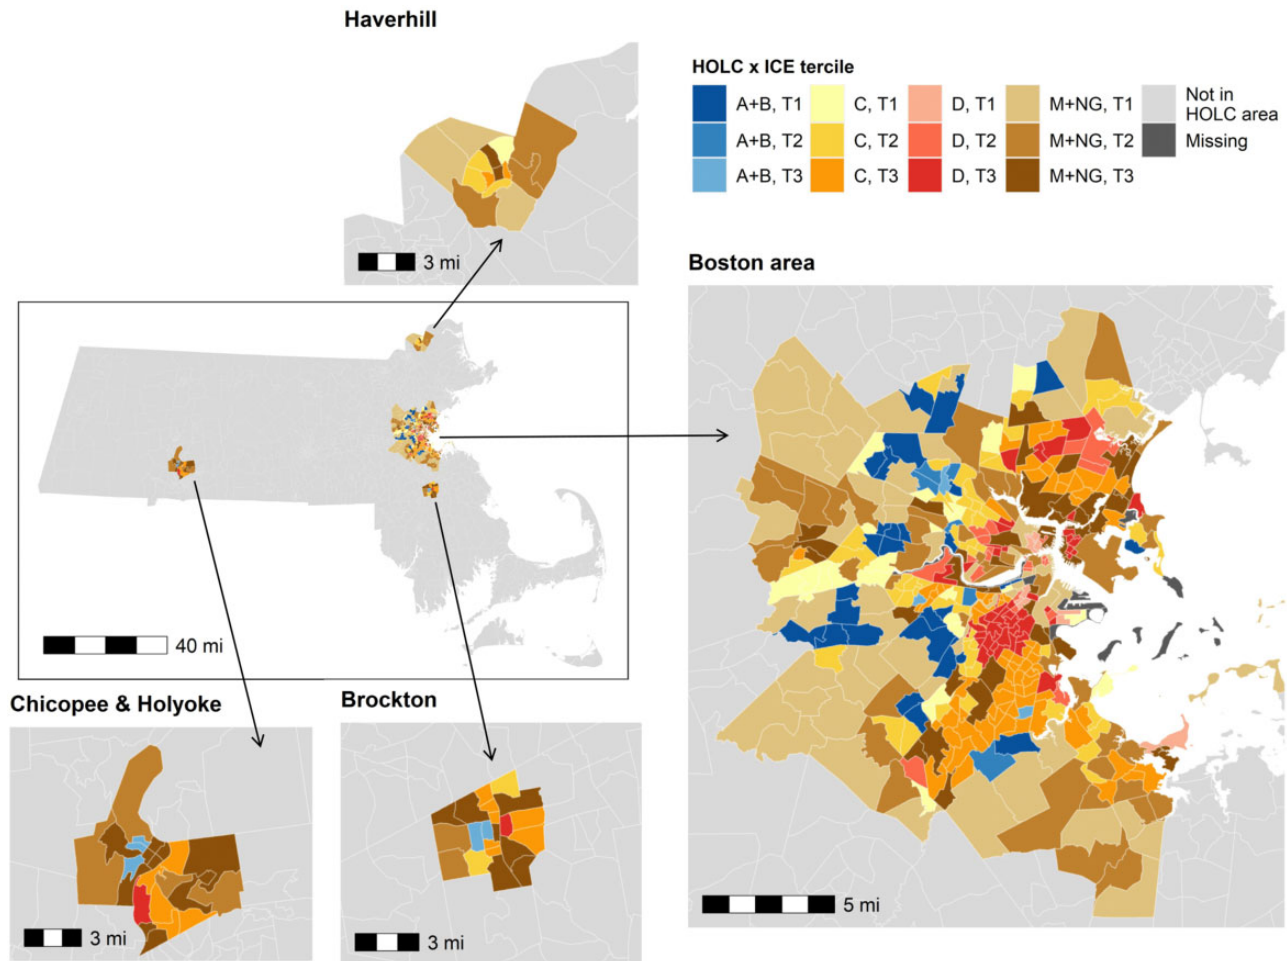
HOLC grade (1937-1938) by ICE for racialized economic segregation tertile (2005-2015) trajectories for Massachusetts CTs ($n = 474$), 2010 boundaries, in municipalities ($n = 28$) with 1930s HOLC maps. HOLC grade operational definition: A/Green = CTs whose land area is [(100% A) OR ($\geq 50\%$ A and $< 100\%$ A)]; B/Blue = CTs whose land area is [(100% B) OR ($\geq 50\%$ B and $< 100\%$ B)]; C/Yellow = CTs whose land area is [(100% C) OR ($\geq 50\%$ C and $< 100\%$ C)]; D/Red = CTs whose land area is [(100% D) OR ($\geq 50\%$ D and $< 100\%$ D)]; Mixed = no category with $\geq 50\%$; No grade assigned = $\geq 50\%$ of land area is unknown. CT ICE measures were calculated for each year in the study period: 2005-2015. CT ICE measures are based on ACS 5-year annual estimates centered in the years 2008 (2006-2010), 2009 (2007-2011), 2010 (2008-2012), 2011 (2009-2013), 2012 (2010-2014), 2013 (2011-2015), 2014 (2012-2016), and 2015 (2013-2017). CT ICE measures for the years 2005-2007 are based on linear interpolation using decennial census data for the year 2000 and the ACS 5-year estimate for 2008 (2006-2010) as anchors. For these maps, CTs were assigned to the ICE tertile they most commonly (mode) were categorized as during the years in the study period. All decennial census and ACS data are normalized to 2010 CT boundaries. ACS = American Community Survey; CT = census tract; HOLC = Home Owners' Loan Corporation; ICE = Index of Concentration at the Extremes; M = mixed; NG = no grade; T1 = tertile 1 (highest concentration non-Hispanic White high-income households); T2 = tertile 2; T3 = tertile 3.
